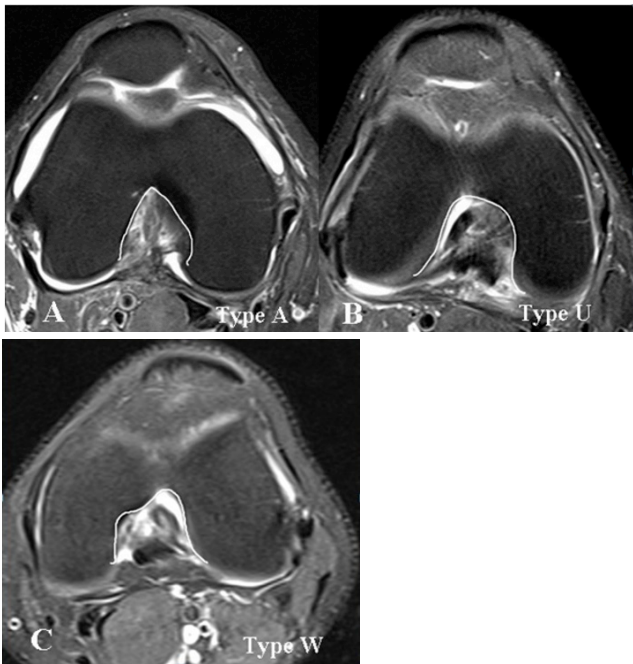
Axial PD (Fat Sat) MRI demonstrating femoral notch shapes; type A, type U and type W.
